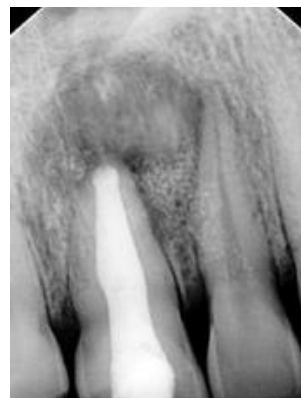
Four months postoperative radiograph
